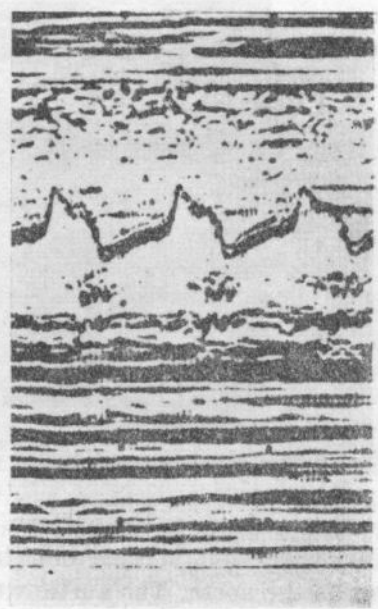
Echocardiogram patterns of mitral valve and tricuspid valve
